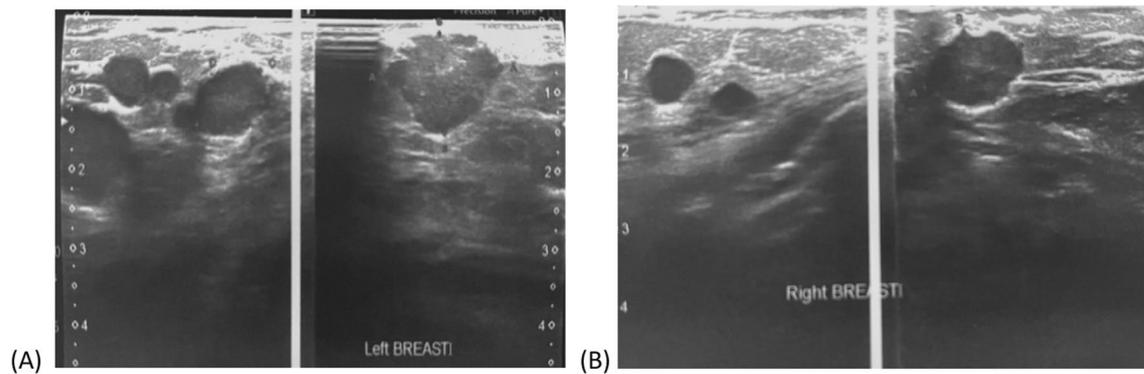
Diagnostic ultrasound of both breasts revealed multiple well-circumscribed soft tissue masses nearly all of them of the same echogenicity with some of them subdermal in location. Most of them are not respecting related tissue planes
